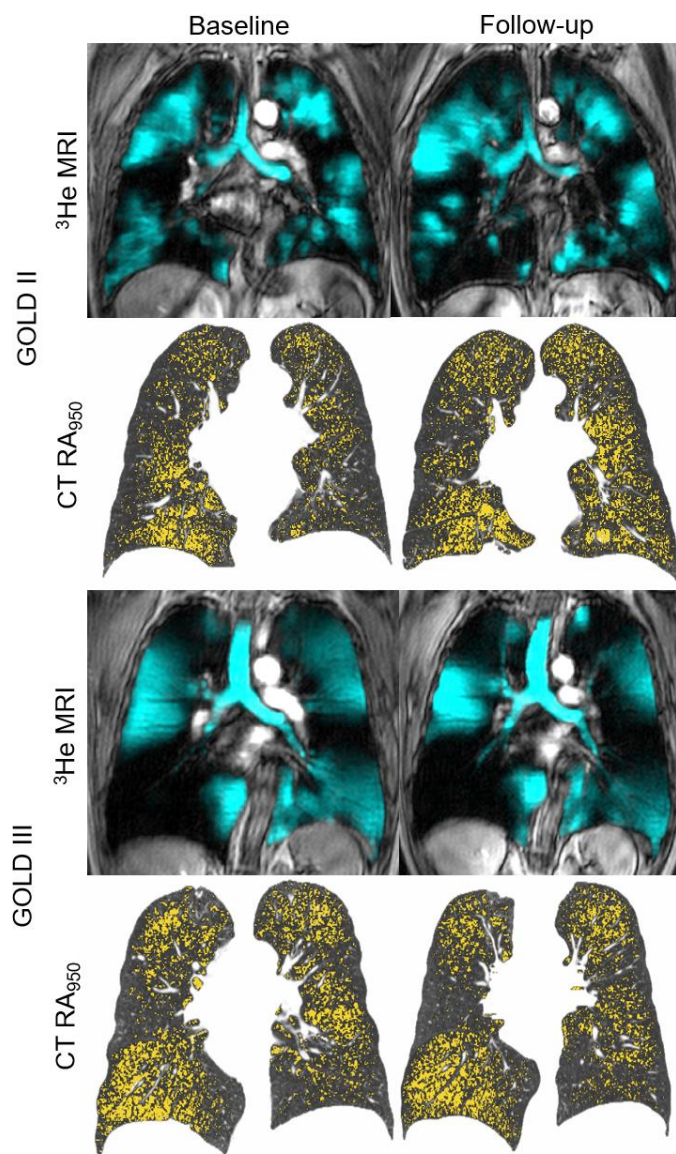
Baseline and follow-up CT and MR imaging for representative participants with COPD.
